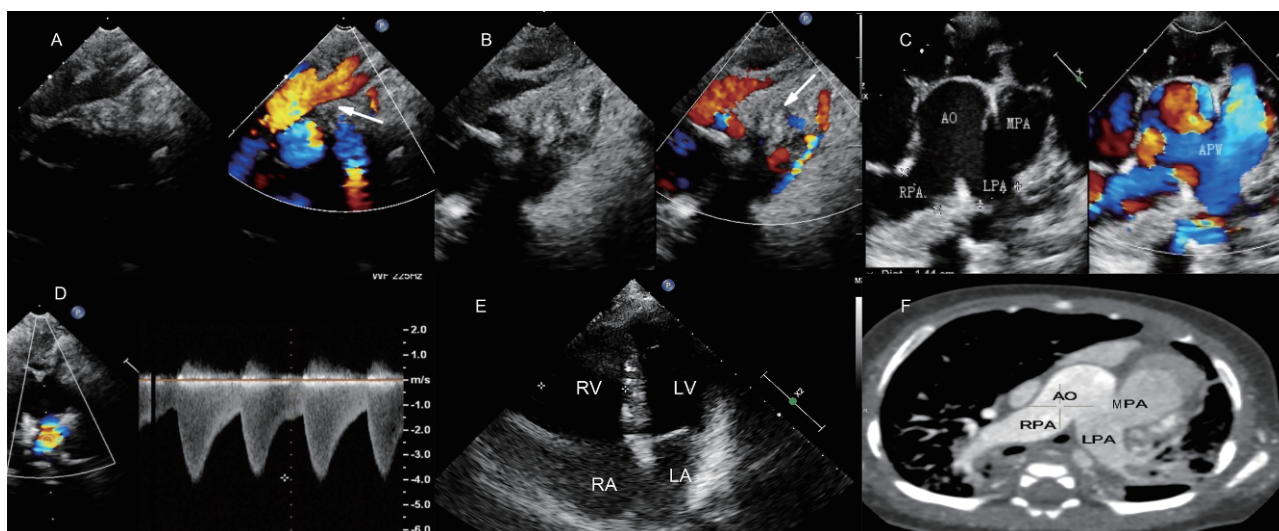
Imaging features of Berry syndrome. A and B, Suprasternal long-axis view showing IAA types A and B (arrow). C, Parasternal short-axis demonstrating the butterfly sign. D, PDA. E, Apical view showing an intact ventricular septum. F, CTA image showing the butterfly sign. AO, aorta; MPA, main pulmonary artery; LPA, left pulmonary artery; RPA, right pulmonary artery; APW, aorta pulmonary window; LA, left atrium; LV, left ventricle; RA, right atrium; RV, right ventricle.
